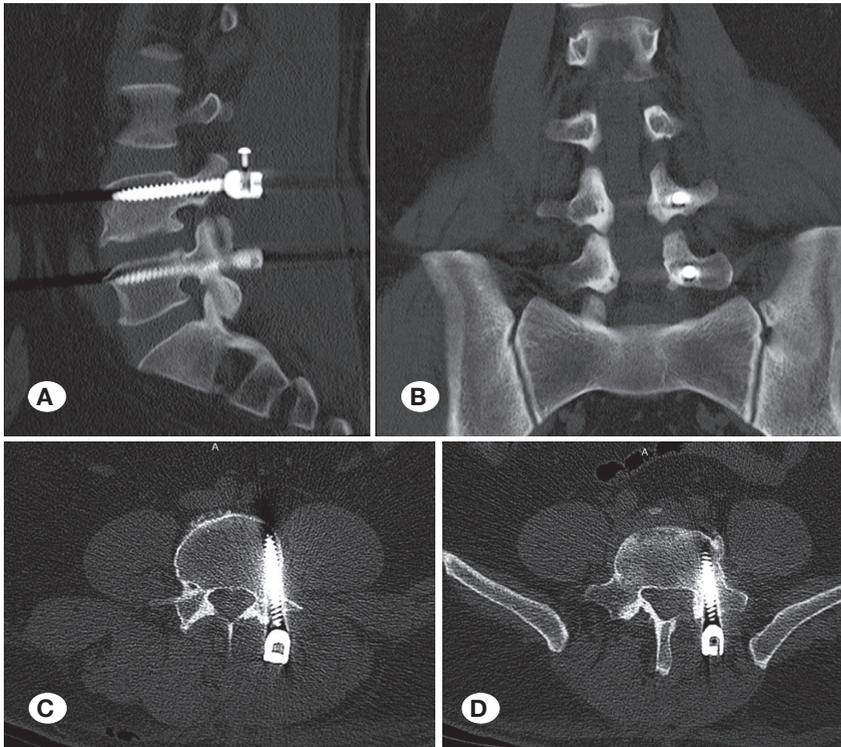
Postoperative lumbar CT images of a patient who was operated on for a left recurrent lumbar disc herniation. A) Sagittal section. B) Coronal section. C) L4 vertebrae axial section. D) L5 vertebrae axial section.
